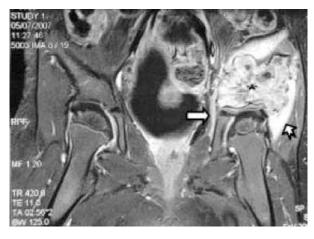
Gadolinium enhanced T1WI MRI in coronal plane showed avidly enhancing left iliac tumor mass (*) with involvement of the left gluteus medius muscle laterally (solid arrowhead) and the left obturator internus muscle medially (arrow). These features are highly suggestive of malignancy.
